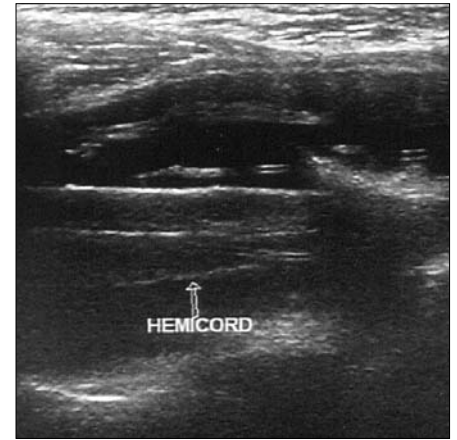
Transverse ultrasonographic image shows the hemicord terminating in the sacral region accompanied by adhesion.
